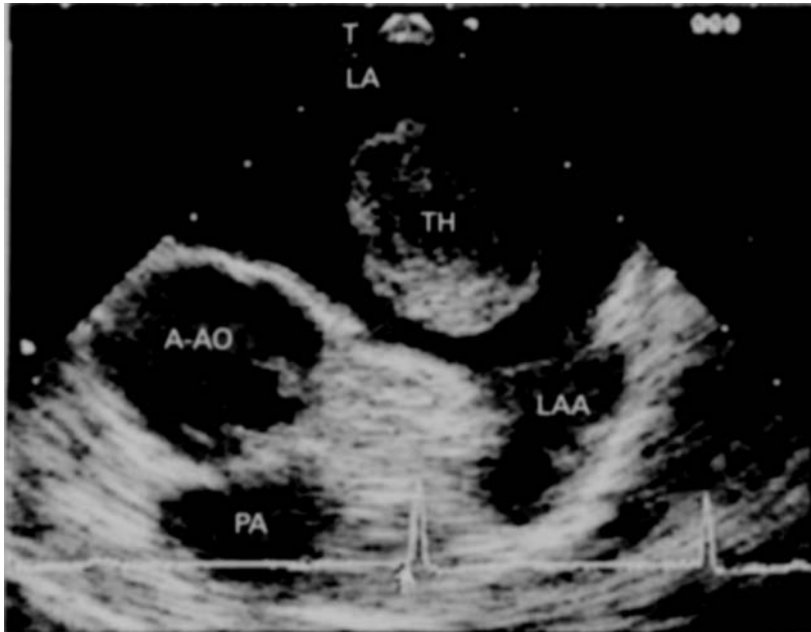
Transoesophageal echocardiogram showing left atrial thrombus (ball-like). A-AO = ascending aorta, LA = left atrium, LAA = left atrial appendage, PA = pulmonary artery, TH = thrombus.
